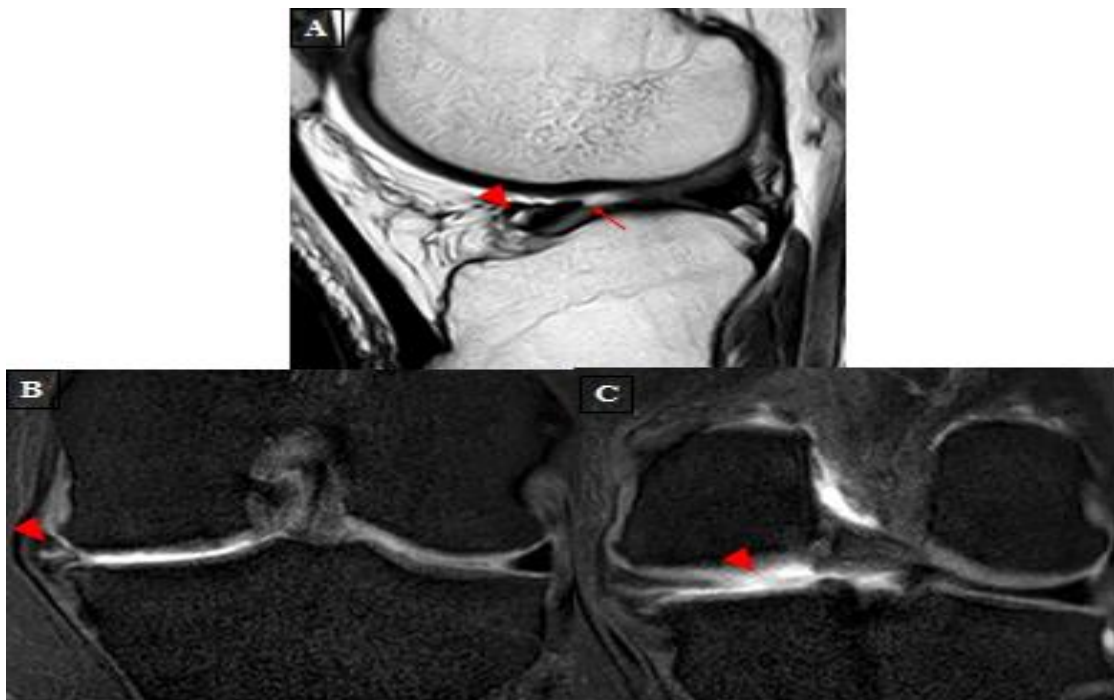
A, B & C): Anterior horn recurrent meniscal tear & root tear. A): Sagittal T2 weighted images showed diminished irregular free edge of medial meniscus after meniscectomy (arrow) with high linear signal in meniscus (arrowhead). B & C): Coronal MR arthrogram T1-weighted fat suppressed images found linear high signal (arrowhead in B) more prominent with extension to the anterior root (arrowhead in C) indicating a recurrent meniscus tear.
